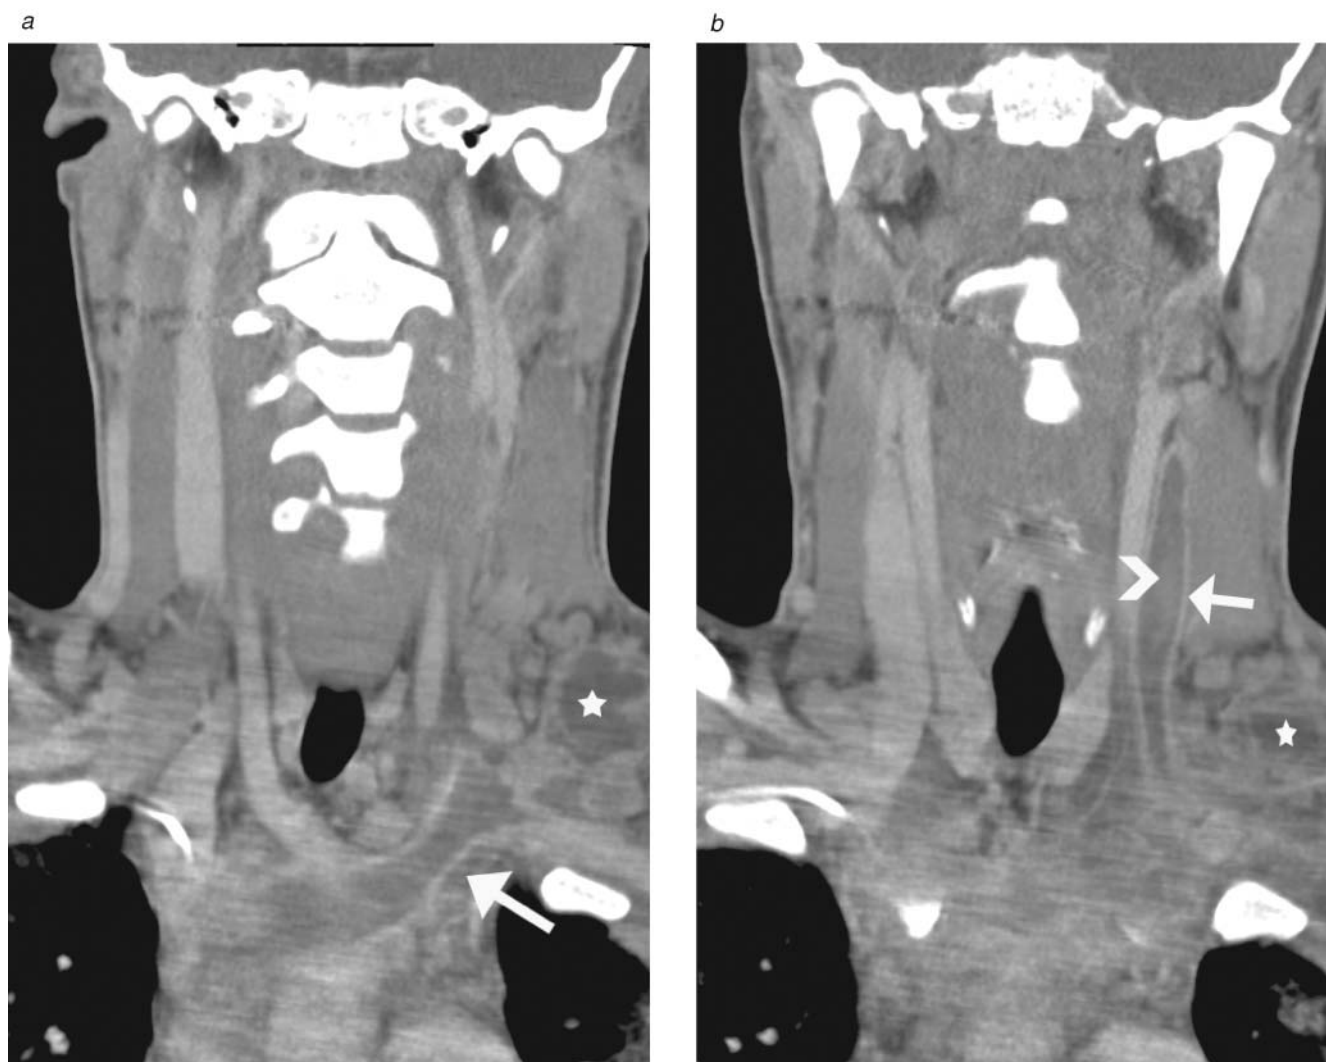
An 18-year-old male presented with a painful mass in the left side of his neck and low-grade fevers. (a) Coronal reconstruction of a multidetector computed tomographic venogram was obtained and demonstrates a focal mass in the left supraclavicular region with a low-attenuation center (*star*) and an enhancing rim. There is extensive low-attenuation material within an expanded left brachiocephalic vein (*arrow*). (b) More posterior coronal reconstruction demonstrates further low-attenuation material within an expanded left internal jugular vein (LIJV) (*arrow*). Note that the material is also enhancing within the vein lumen (*arrowhead*). The focal mass in the left supraclavicular region with a low-attenuation center (*star*) and an enhancing rim is also seen. These findings are consistent with a septic thrombus within the LIJV extending into the left brachiocephalic vein as a result of the left supraclavicular abscess. This constellation of findings is known as Lemierre syndrome. The neck abscess was drained percutaneously under ultrasound guidance, and the patient was treated with intravenous antibiotics, with resolution of fevers.
